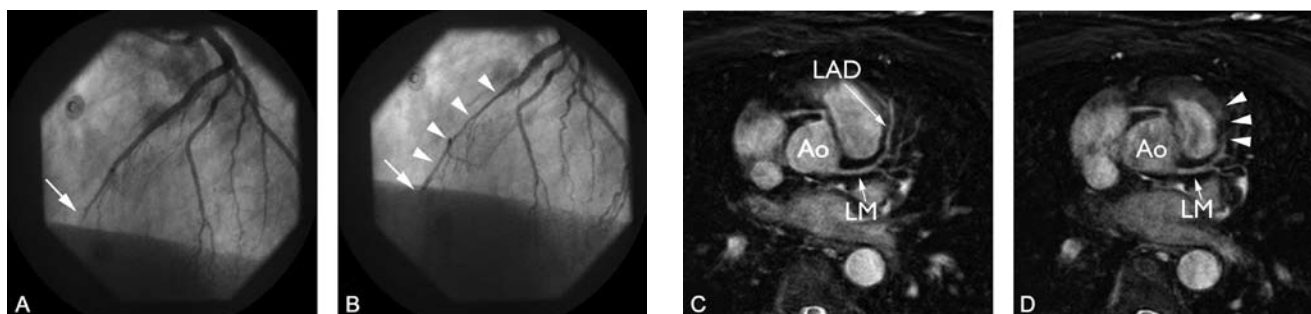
Coronary angiogram (A, B) and targeted Cartesian balanced steady-state free precession (bSSFP) MRI with mid-diastolic (C) and systolic imaging (D) in a 52-year-old man with acute anterior wall myocardial infarction. Coronary angiography revealed single-vessel disease of the left anterior descending artery (LAD). In A, distal occlusion of the LAD can be seen (arrow). B, systolic squeezing of the intramyocardial mid-LAD (arrowheads). C, the proximal and mid-segment of the LAD can be seen during diastole, however, this segment disappears during systole (D, arrowheads). Ao: aorta, LM: left main stem.
